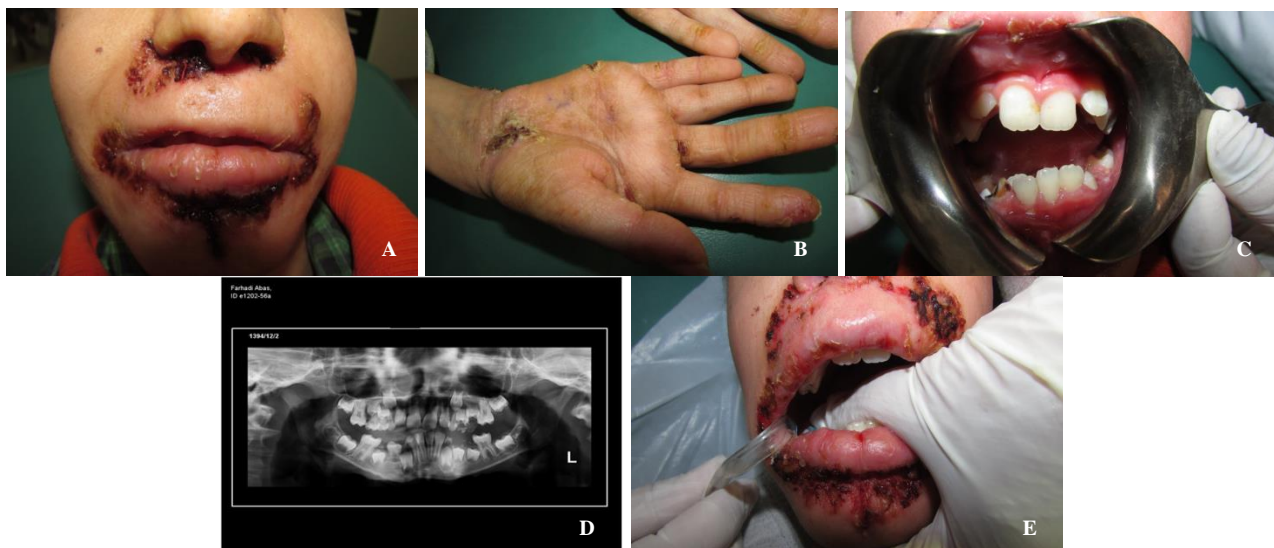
Erythematous lesion around the mouth of the 8-year-old patient (A), crusted lesion on palms (B), normal permanent anterior teeth in mixed dentition in older patient (C), panoramic radiography of the 8-year-old patient (D), etching stage in fissure-sealant therapy (E)
